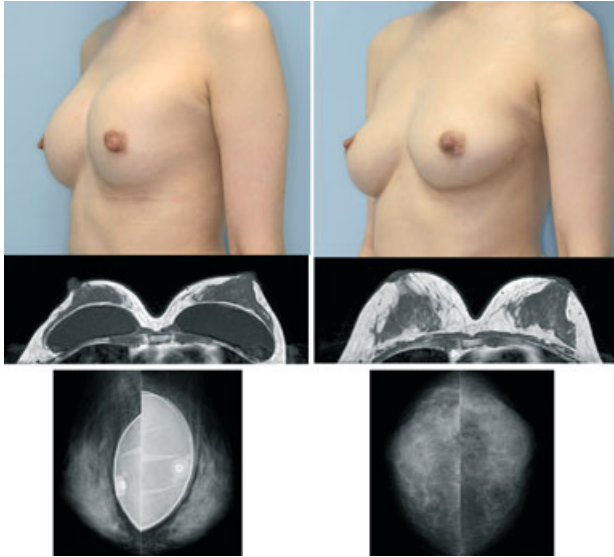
Clinical and radiological views of Case 1. Preoperative (left panels) and postoperative (right panels) views at 12 months. Clinical views showed capsular contracture and upward displacement of the left implant before surgery (top, left), while the breasts had a natural and symmetrical appearance at 12 months (top, right). T1-weighted MRI (middle, left, and right) revealed that the transplanted adipose tissue survived and formed thick layers around and under the mammary gland at 12 months. Mammograms showed that neither implant was ruptured before surgery (bottom, left) and that no calcification or other abnormal signs were visible in either breast at 12 months (bottom, right). Augmented breast mounds maintained sufficient breast volume even after implant removal, and were naturally soft without any subcutaneous indurations (see also Video S1).
